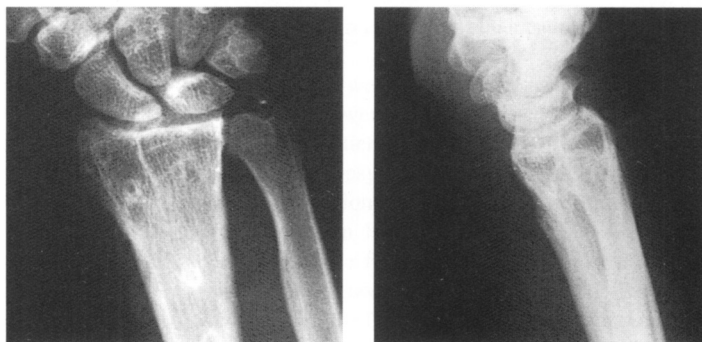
Preoperative radiograph of an 18-year-old man with a B3.2 volar Barton fracture.
